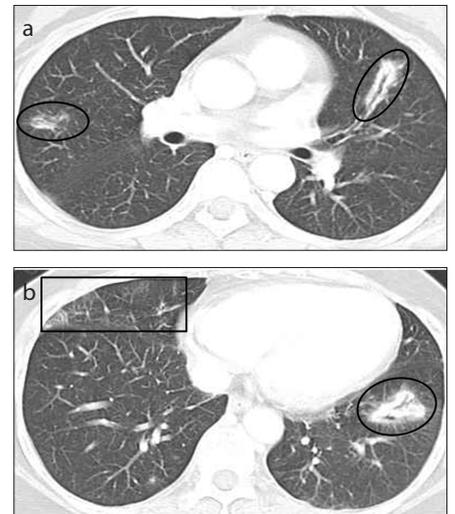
a, b. A 49-year-old woman with acute ATL. Chest CT image (a) shows thickening of the bronchovascular bundles in both lungs (ovoid circles), which also forms a localized consolidation in the left lower lobe. Mild ground-glass attenuation and interlobular septal thickening are observed in the right middle lobe (b, rectangle). These abnormal shadows disappeared after chemotherapy.
